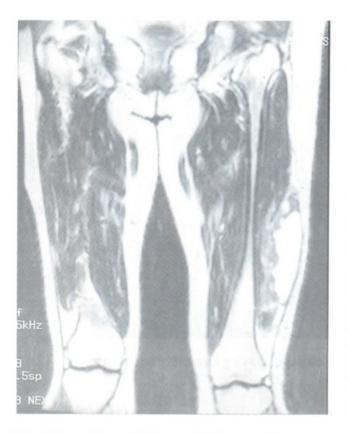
(b) Coronal T2-weighted images demon strates a high signal intensity fluid collection in the left vastus lateralis. Adjacent inflammatory change in the left vastus lateralis muscle, seen as infiltrative areas of hyperintensity.
